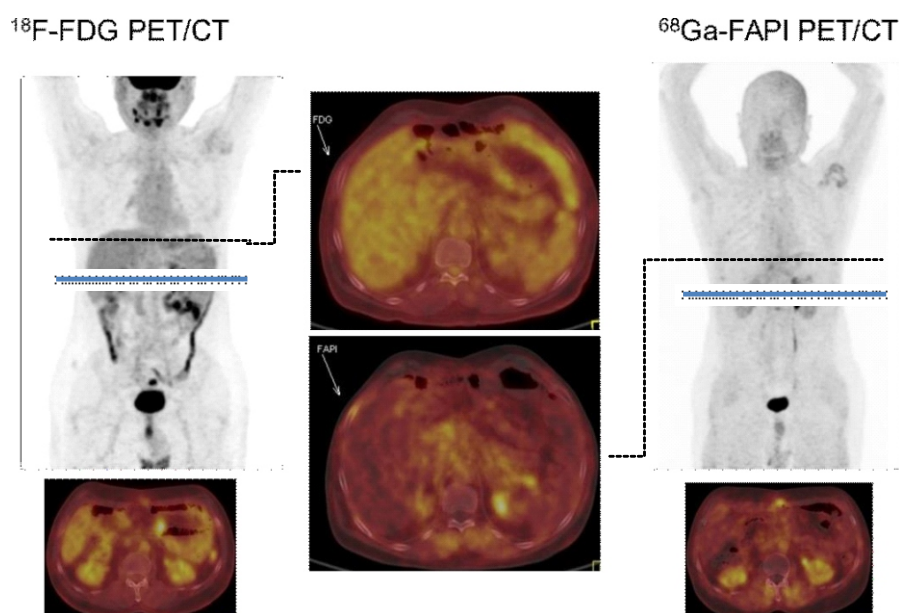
A 65-year-old male with a known case of gastric adenocarcinoma underwent gastrectomy and received CRT. This patient was referred to our center with a rising tumor marker (CA 19-9) and recurrence evaluation. Fibroblast activation protein inhibitor uptake in the focal peritoneal thickening in the midline of the abdomen at a level of L2 (without ^{18}F -FDG hypermetabolism). The mentioned rib lesions showed moderate uptake with ^{18}F -FDG non-avidity.
